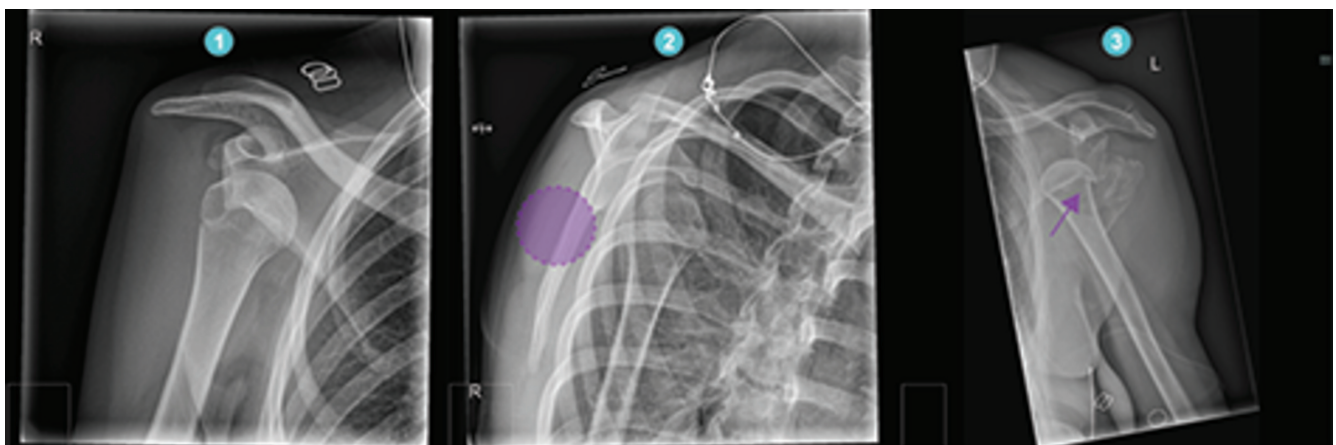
Anteroposterior radiograph (1 and 3) and a scapular 'Y' radiograph (2). (1) The humeral head is positioned in front of the glenoid, which confirms a dislocation. (2) Shows a scapular 'Y' view that can help to distinguish an anterior from a posterior dislocation. The dotted circle shows where the humeral head would have to be positioned to confirm a posterior dislocation. (3) Shows a confirmed shoulder dislocation with a greater tuberosity fracture. Radiographs reproduced from the database of the Diaconessenhuis by the authors
